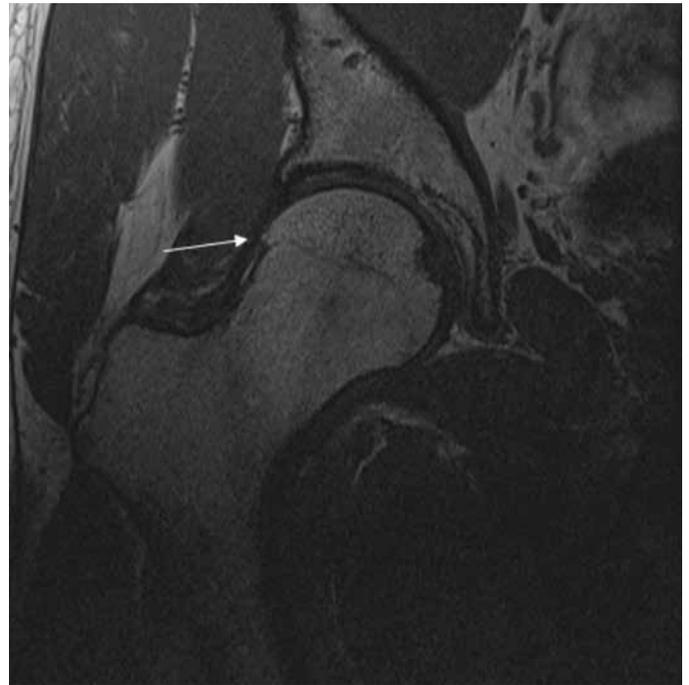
T1-weighted coronal MRI: Bony spur consistent with cam-type impingement lateral to right femoral head-neck (arrow)
